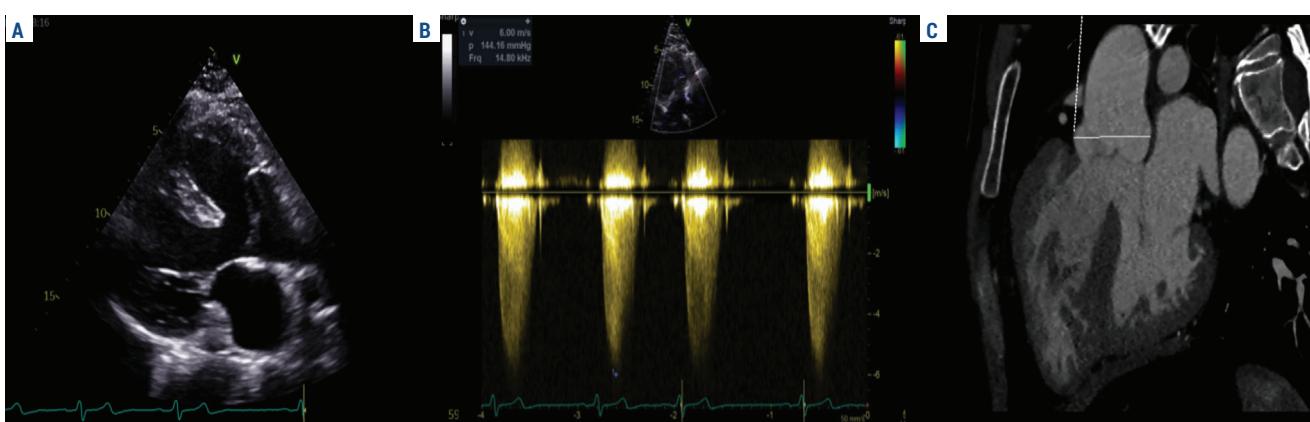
Echocardiography and CT scan of unoperated tetralogy of Fallot, showing a large ventricular septal defect with overriding aorta (A, C) and high gradient through stenotic pulmonary valve (B).
